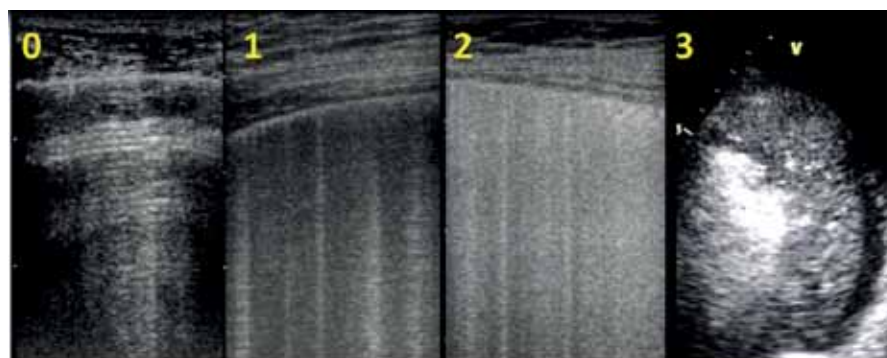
Progressive loss of aeration and corresponding lung ultrasound score from normal (left) to complete loss of aeration (right) – transversal view, linear probe [0-2] and phased-array probe [3].
